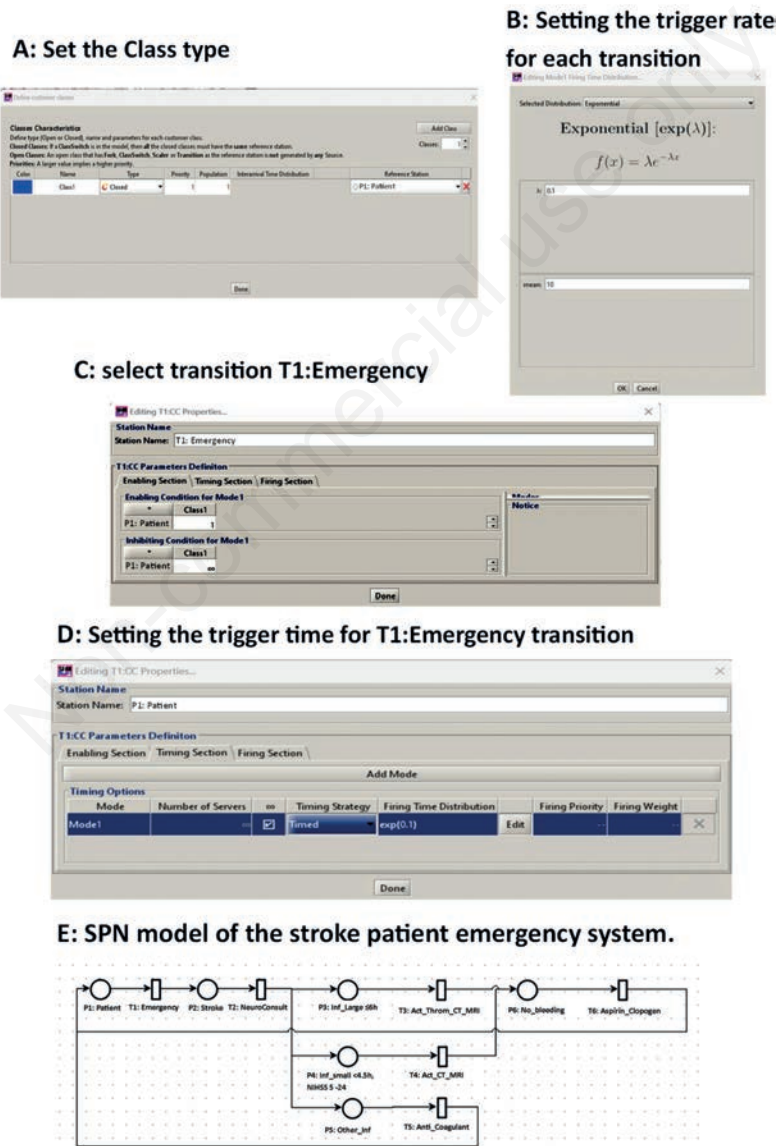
Setting up the Petri network. SPN, stochastic Petri net; NeuroConsult, Neurologist Consultation; Inf, Infarction; Act, Actylise; Throm, Thrombectomy; CT, Computed Tomography; MRI, Magnetic Resonance Imaging; NIHSS, The NIH Stroke Scale/Score.
